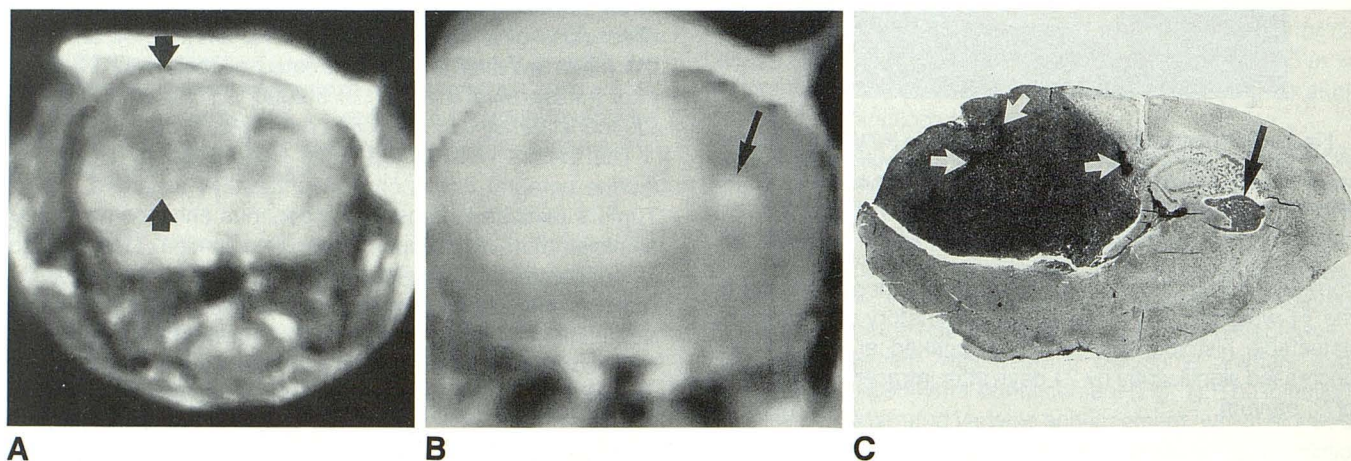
Comparison of MR image with whole brain mount 16 days after intracerebral injection of 50,000 KHT sarcoma cells.
